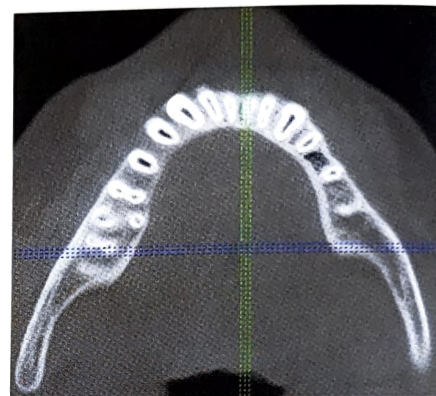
CBCT demonstrates axial 2-D slices of 46 showing extra root; Middle third
